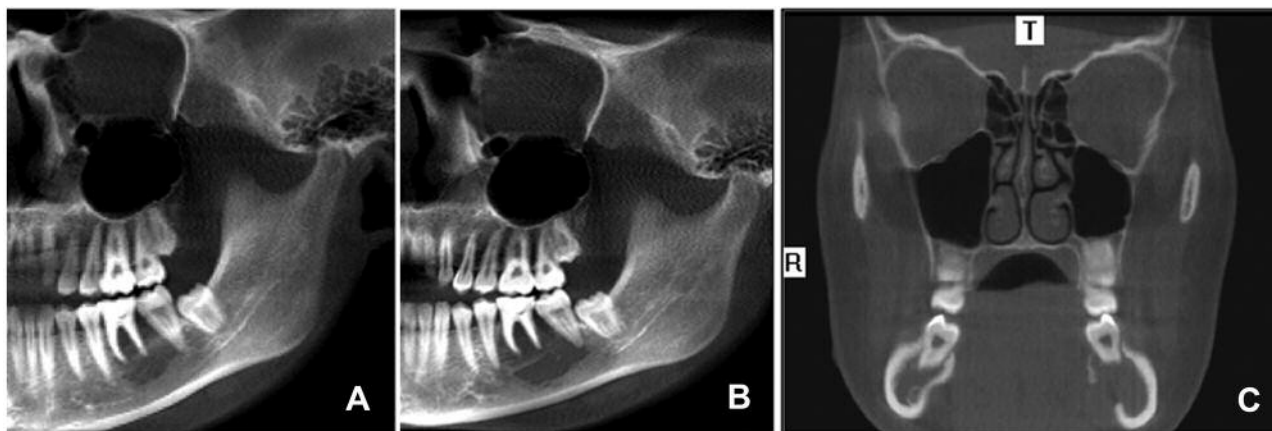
Cone beam computed tomography of Ewing's sarcoma/peripheral primitive neuroectodermal tumor showing enlargement of hypodense osteolytic area (A and B) and coronal section showing lingual cortical bone resorption close to the first molar (C).
